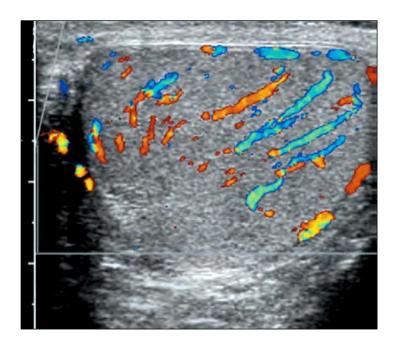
Transverse USG scan with color Doppler showing normal testicular vascularity.
